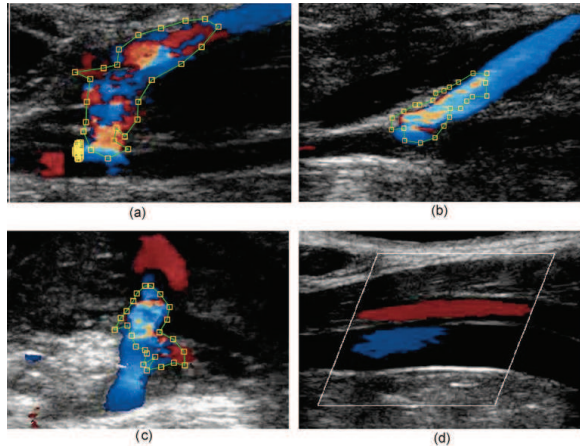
Hemorrhage detection using Doppler ultrasound imaging. Frames a, b, and c show different cases of potential hemorrhage. Frame d is a control image with normal blood flow.
